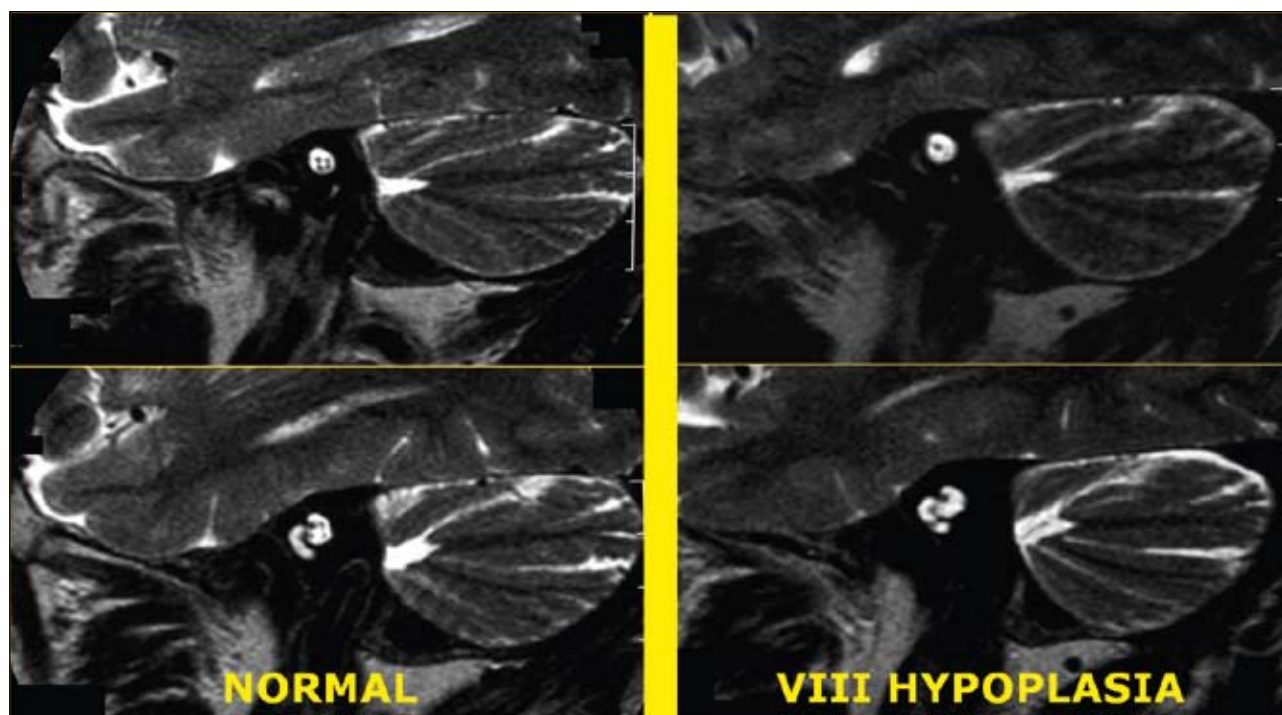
Comparison of a normal and hypoplastic 8th nerve on T2 weighted para-sagittal. MR imaging. Note the 4 nerves in the internal meatus in the normal image and the facial nerve and hypoplastic 8th nerve on the right.
